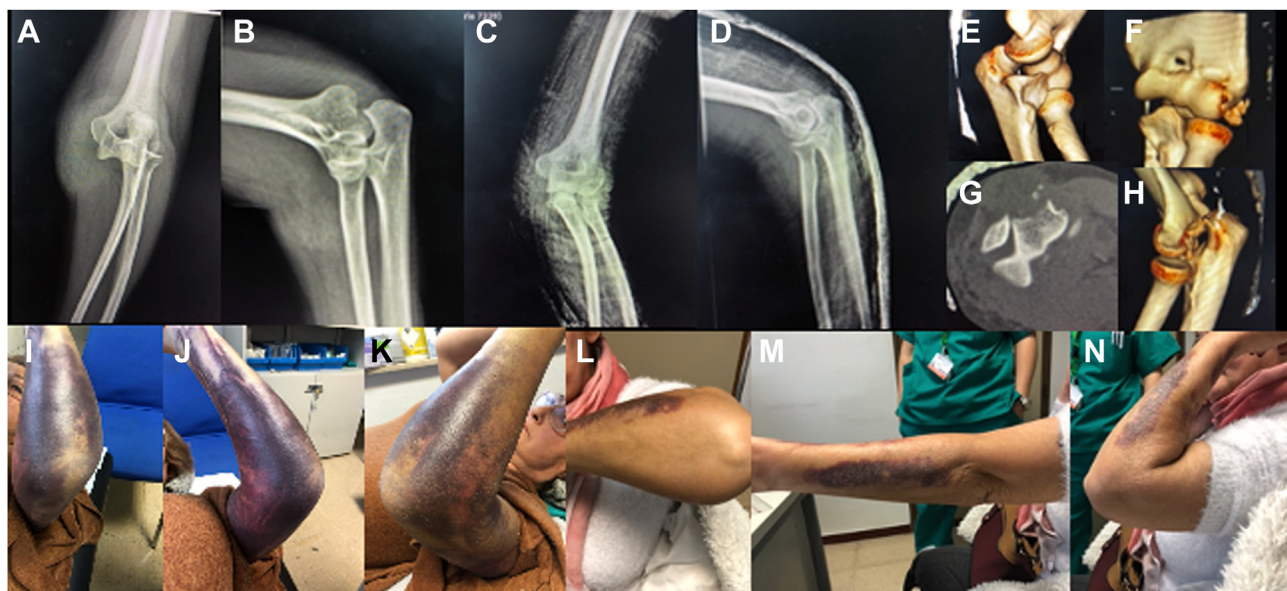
(A and B) A 62-year-old female suffered a fall on the outstretched hand suffering a posterolateral elbow dislocation of her left arm. (C and D), She was reduced in the emergency room and on post-reduction imaging an increased medial joint line space was present. (E-H), A computed tomography exam was obtained in which an Osborne-Cotterill injury of the posterior capitulum was appreciated along with signs of instability. The elbow was placed in a cast with slightly more elbow flexion and was seen in the clinic 5 days later. (I-K), The cast was removed and her physical exam showed a huge hematoma of the arm, more significant on the medial side. She was not apprehensive and was instructed on performing supine protective exercises, and was seen 5 weeks later in the clinic. (L-N), She had regained full range of motion and had no symptom of instability.
